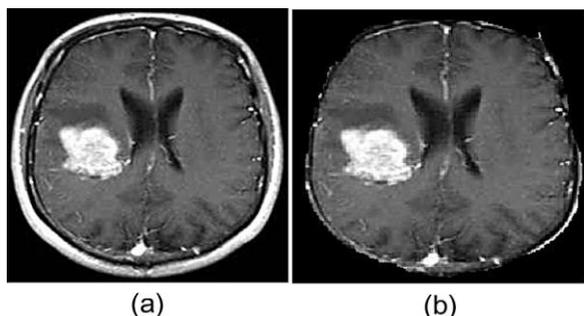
(a) MRI Image as Input (b) Removal of skull
